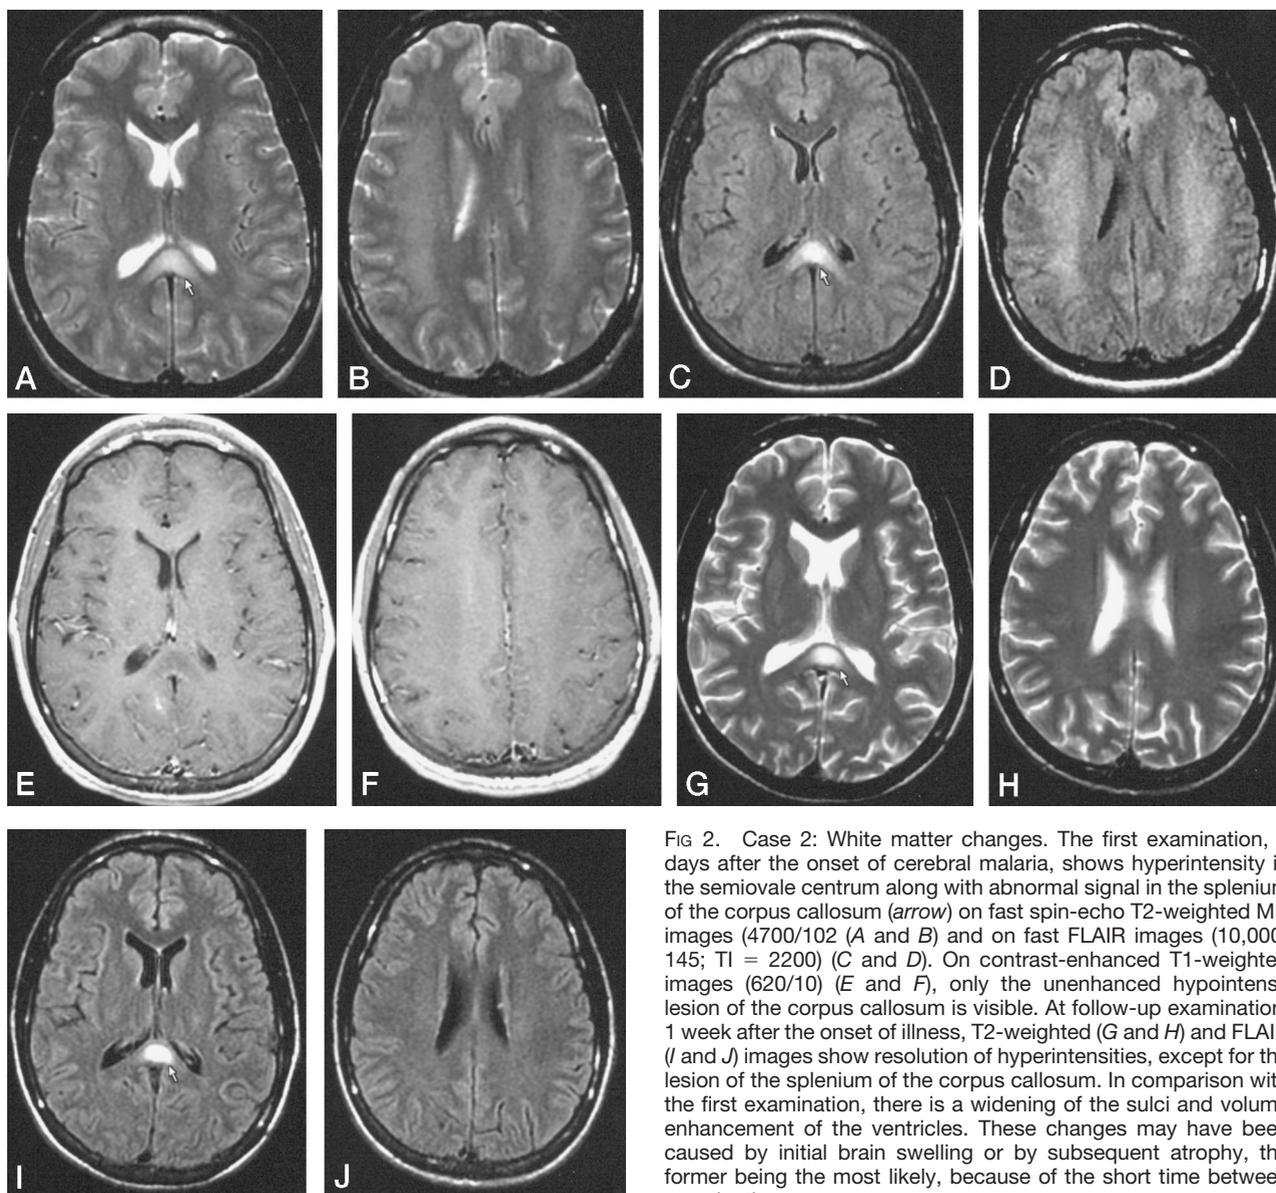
Case 2: White matter changes. The first examination, 2 days after the onset of cerebral malaria, shows hyperintensity in the semiovale centrum along with abnormal signal in the splenium of the corpus callosum (arrow) on fast spin-echo T2-weighted MR images (4700/102 (A and B) and on fast FLAIR images (10,000/145; TI = 2200) (C and D). On contrast-enhanced T1-weighted images (620/10) (E and F), only the unenhanced hypointense lesion of the corpus callosum is visible. At follow-up examination, 1 week after the onset of illness, T2-weighted (G and H) and FLAIR (I and J) images show resolution of hyperintensities, except for the lesion of the splenium of the corpus callosum. In comparison with the first examination, there is a widening of the sulci and volume enhancement of the ventricles. These changes may have been caused by initial brain swelling or by subsequent atrophy, the former being the most likely, because of the short time between examinations.
